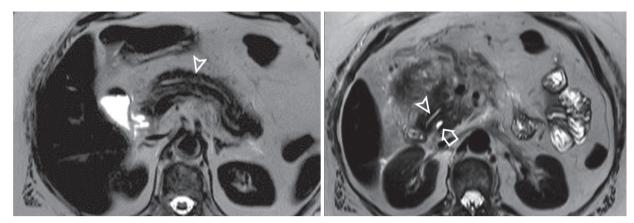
Pancreas Divisum. MR image shows the dorsal pancreatic duct in continuity with the duct of Santorini (white arrow-head) crossing anterior to the common bile duct (white arrow), draining at two different sites.
